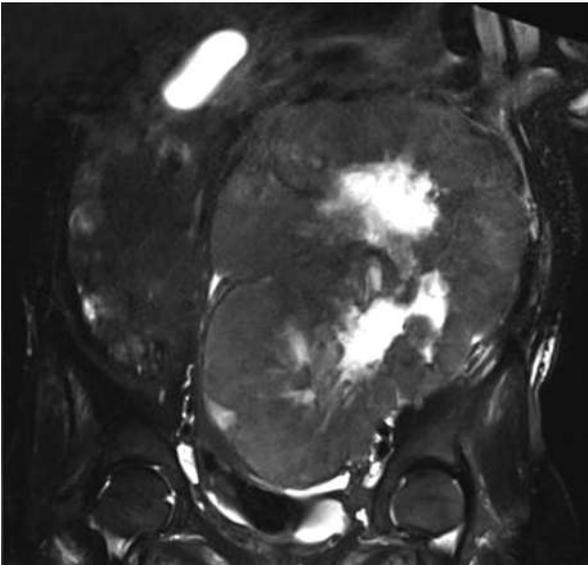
T2-weighted fat-saturated tomogram shows a large lobulated mass in the left hemiabdomen with central necrosis of unknown origin
